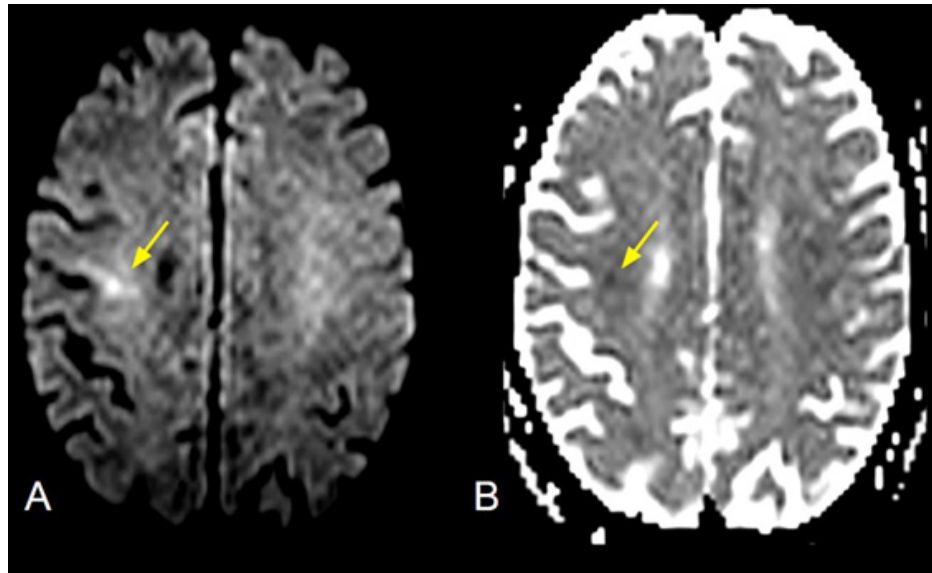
Brain magnetic resonance imaging showed a focal area in restricted diffusion in diffusion weighted image (a), with low signal in apparent diffusion coefficient (b), compatible with acute ischemic stroke in the right middle cerebral artery territory.
